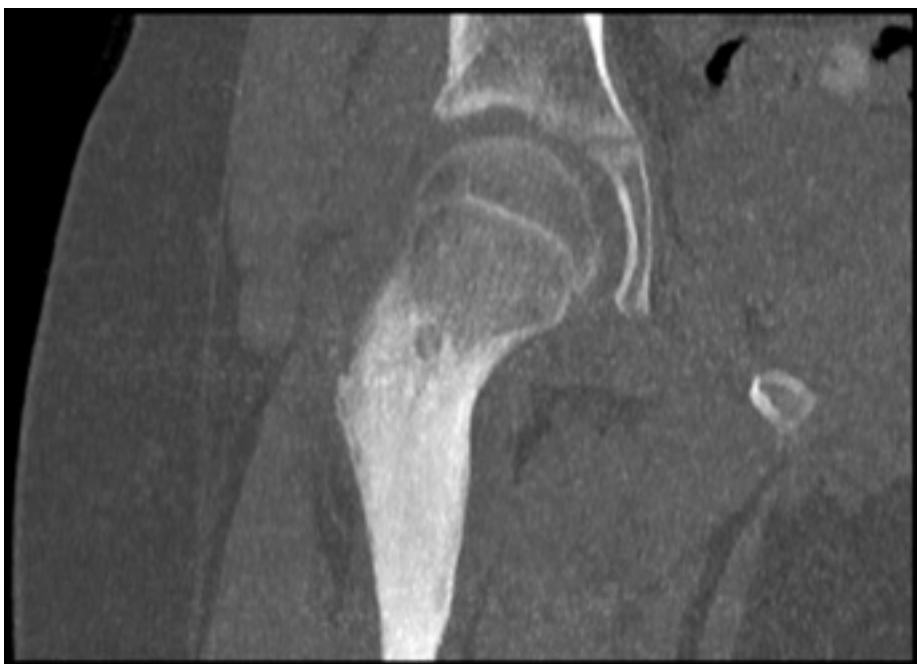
Coronal MRI of the upper femur
